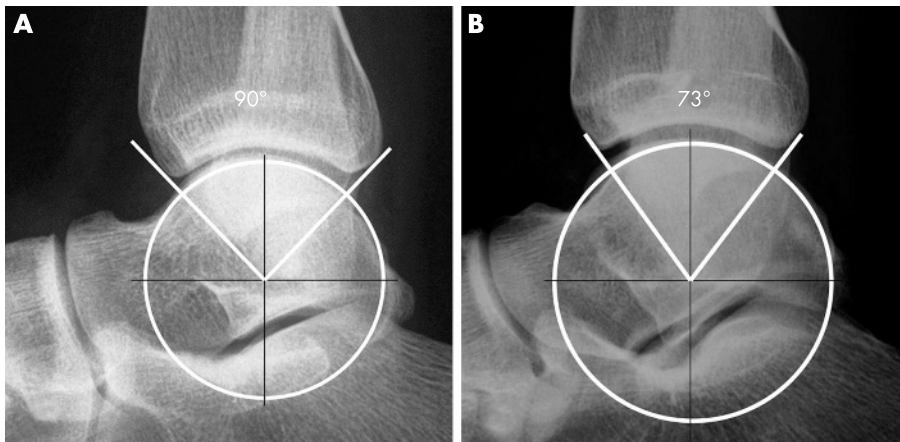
Lateral x ray of a normal and an unstable ankle joint. Radiographs of (A) a typical stable joint configuration with a larger sector and smaller radius, and (B) a typical unstable configuration with a smaller sector and larger radius.
